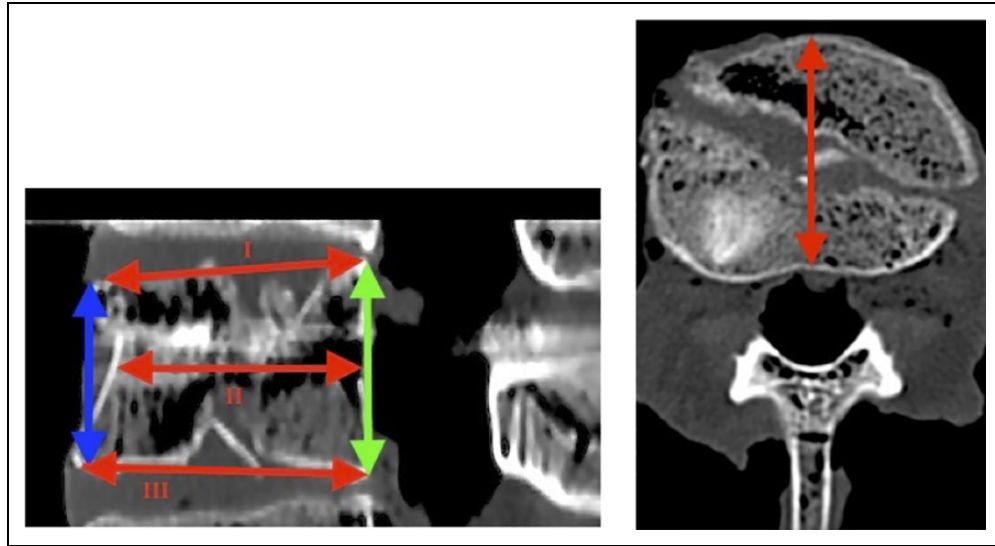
Computed tomography scan of a fractured vertebral body (lateral [left] and coronal [right] view). Red arrows indicate: I: length of cranial endplate, II: length of vertebral midline, III: length of caudal endplate. Green arrow indicates posterior vertebral height; blue arrow indicates anterior vertebral height.
